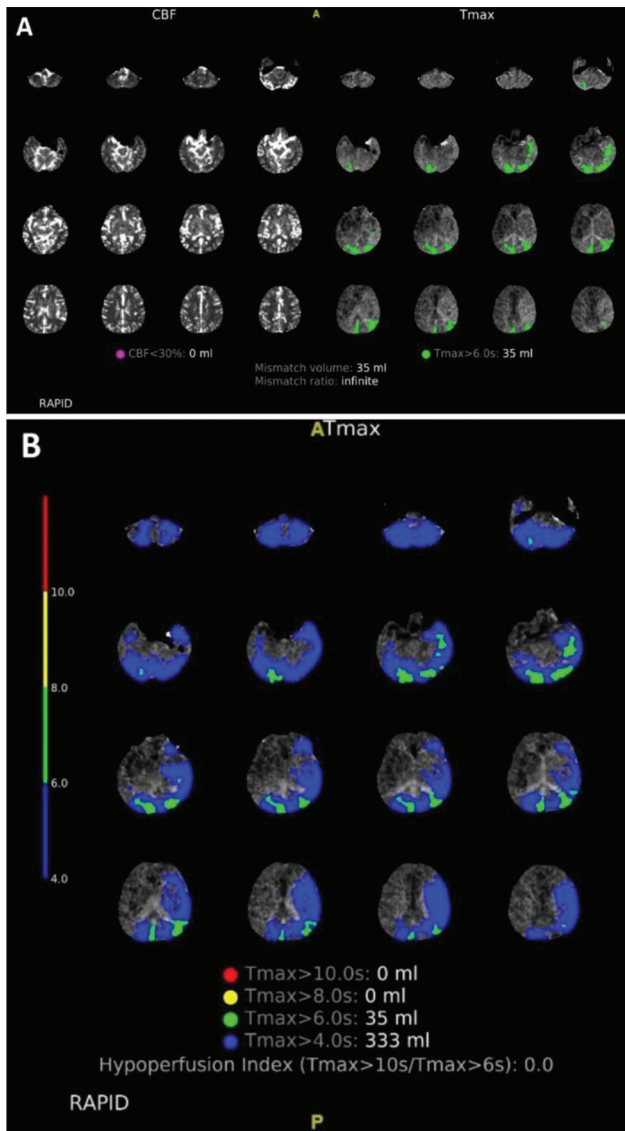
CT Perfusion imaging processed by RAPID Artificial Intelligence software showing no ischemic core infarcts (A: Cerebral blood flow less than 30% volume is 0mls) and perfusion deficit with a time-to-maximum (Tmax)-more-than-6-seconds volume of 35mls, indicating hypoperfusion in the left parieto-temporal region (green). A low Hypoperfusion Index correlates with presence of good collateral circulation (B).
